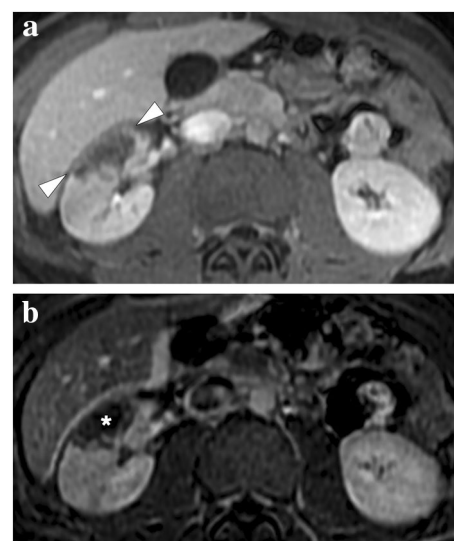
A 19-year-old male patient with known hereditary thrombophilia presented with recent onset right flank pain. An initial US examination was unremarkable except for mild heterogeneity, without any obvious mass lesion, in the interpolar region of the right kidney (not shown). a Axial plane T1-weighted dynamic post-contrast abdominal MR image showed a triangular-shaped hypointense, non-enhancing area (arrowheads) in the right kidney, which was found to be suggestive of renal infarction. b Axial plane subtraction image confirmed the absence of focal contrast enhancement (asterisk)
